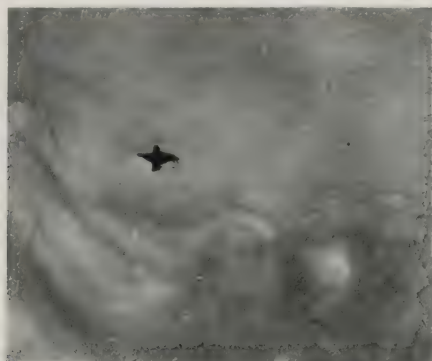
x-Ray picture of sella turcica, marked +, excavated by pituitary tumor. No acromegaly present.
